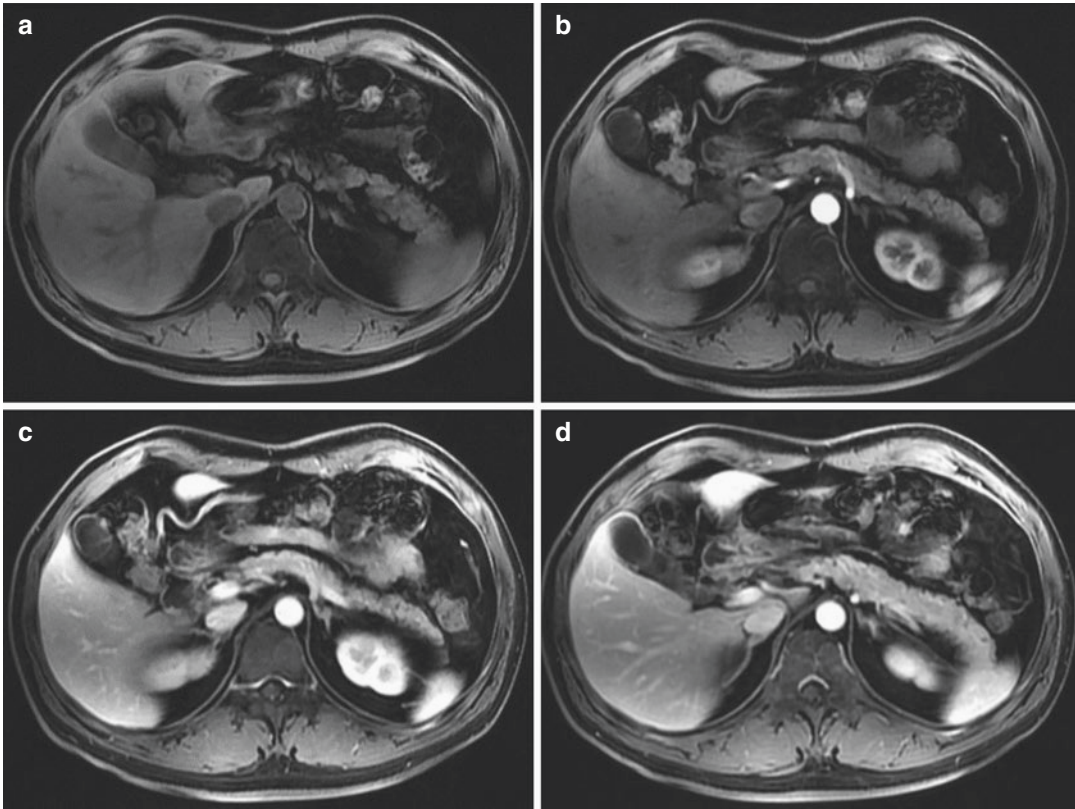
Suspected chronic pancreatitis on MRI. A 46-year-old patient with isolated segmental finding. Axial T₁-weighted fat-saturated spoiled gradient echo image (a) demonstrate the normal size and signal of pancreas.
